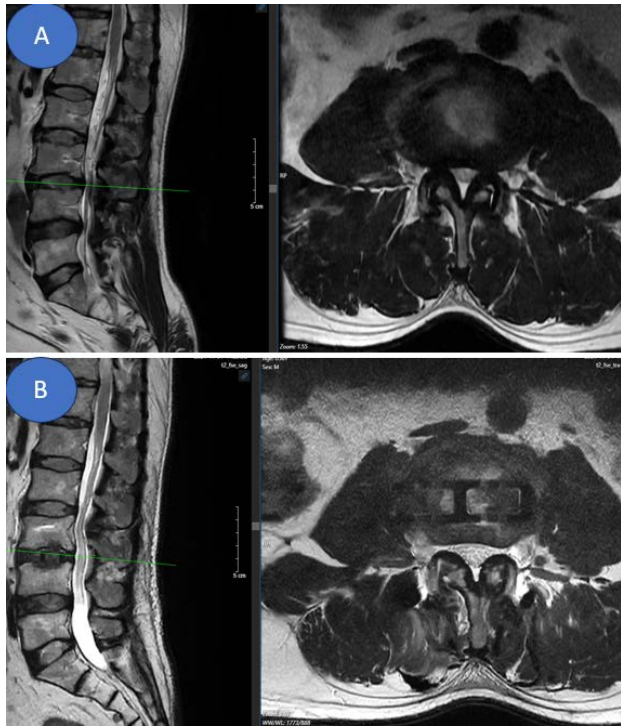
Change MRI in spinal canal area pre-operation (A) and 1 month after surgery (B).
